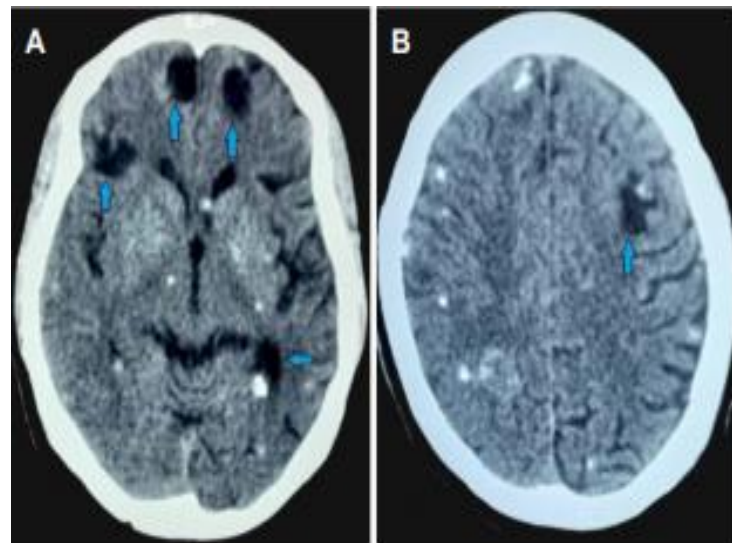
An axial segment of a non-contrast brain CT scan reveals the following: (A) many hypodense, oval-shaped lesions in both cerebral hemispheres, with the greatest lesions located in the left frontal, right parietal, and right frontal lobes (blue arrows). Both hemispheres also contain several tiny calcific concentrations. (B) An oval-shaped, hypodense lesion with many small-sized calcific densities in both cerebral hemispheres (blue arrow). CT - computed tomography.
